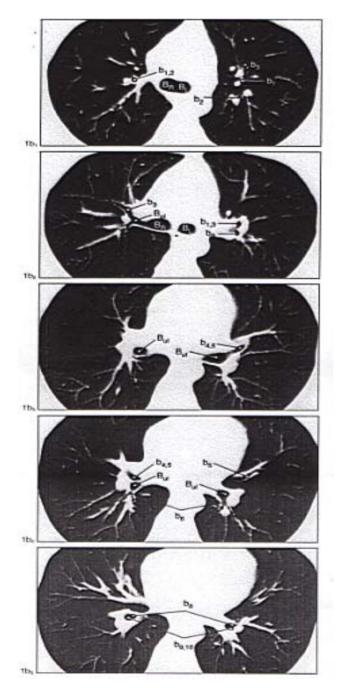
Showing: Normal CT anatomy of the bronchial tree (Quoted from Wegener, 1992).
